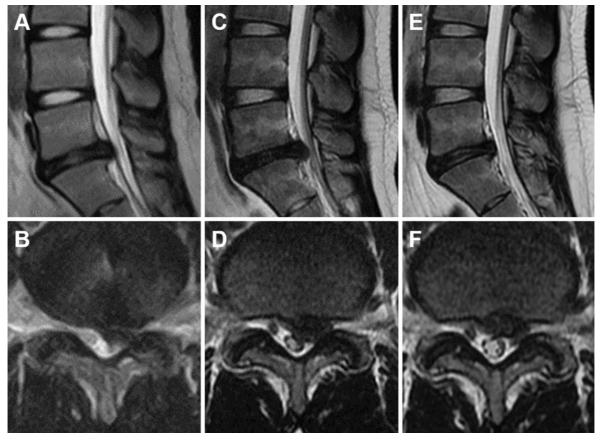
Case 1: A 19-year-old man complaining of left lower-extremity pain for 8 months. Baseline sagittal (A) and axial (B) T2-weighted magnetic resonance imaging (MRI) scans showing disk herniation at L5/S. Sagittal and axial MRI scans obtained 3 months (C and D) and 1 year (E and F) after condoliase injection. The disk height and signal changes at 3 months after injection were lower than those observed before the injection. The patient had recovered at 1 year and showed a reduction in disk herniation.
